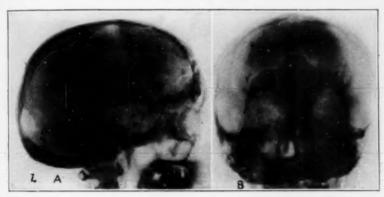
Roentgenograms taken Sept. 29, 1928. Note the involvement of both frontal sinuses in lines of fracture. There is no intracranial air. A, indicates the left side of the head; B, the right.
